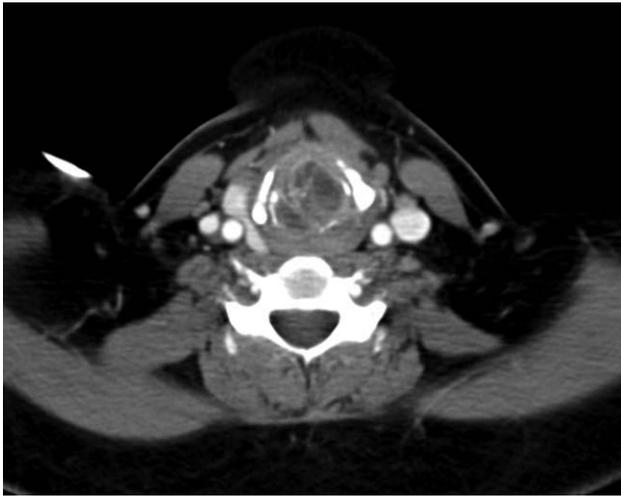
Axial, contrast-enhanced computed tomography demonstrating a mass at the level of the cricoid, with evidence of thyroid and cricoid cartilage erosion.
